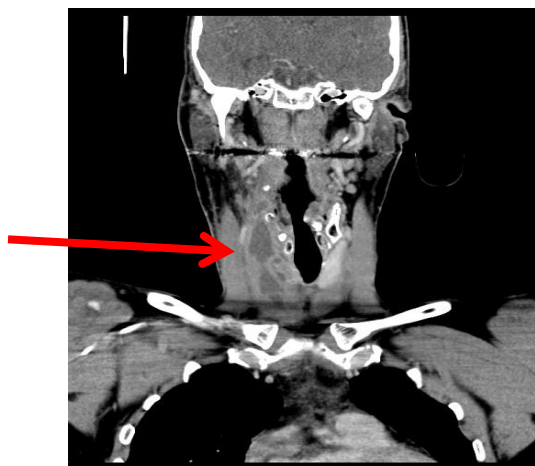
CT scan demonstrating the large thyroid abscess (red arrow)
